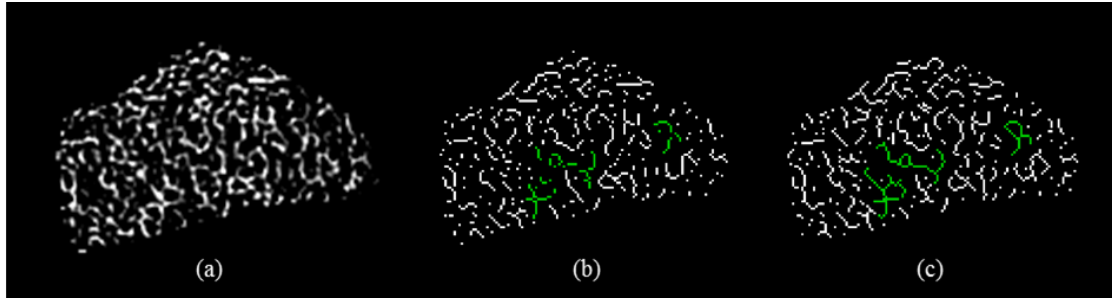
Connectivity preservation of TB network using binary and fuzzy skeletonization methods. (a) The BVF map in an axial image of distal radius acquired in vivo at 1.5 T MRI. The regions with relatively thin trabeculae are highlighted with arrows. (b,c) Results of binary and fuzzy skeletonization. In-plane connectivity loss in the binary skeleton in (b) is highlighted in green; the matching trabeculae in (c) are also highlighted.
